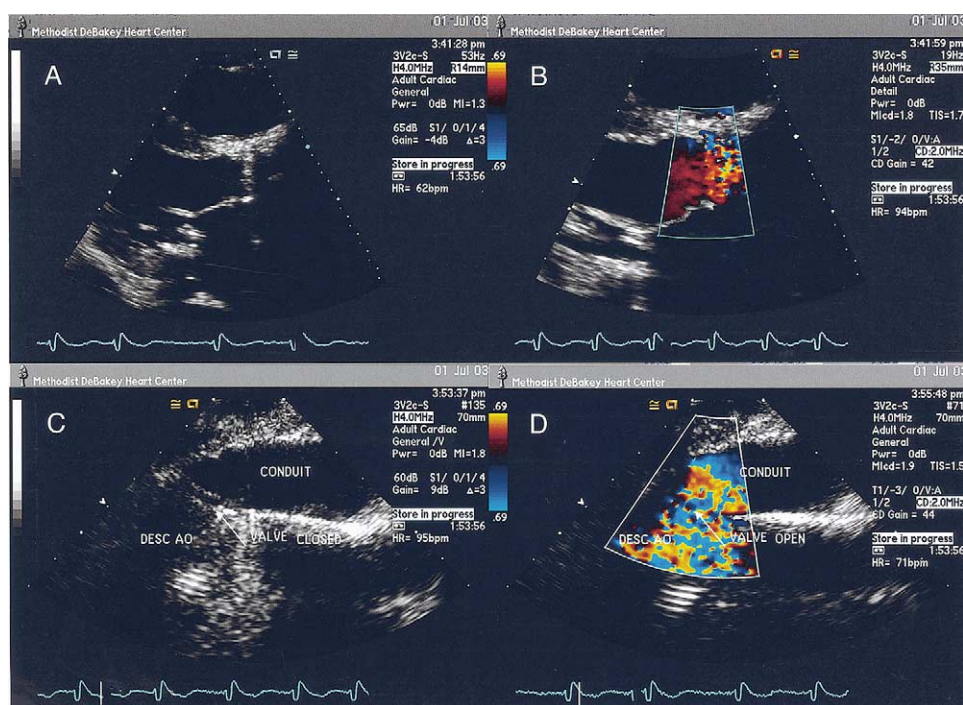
Recent echocardiography. A, Valve prosthesis in aortic position. B, Flow through aortic valve prosthesis. C, Apicoaortic conduit with mechanical valve. D, Flow through conduit.
